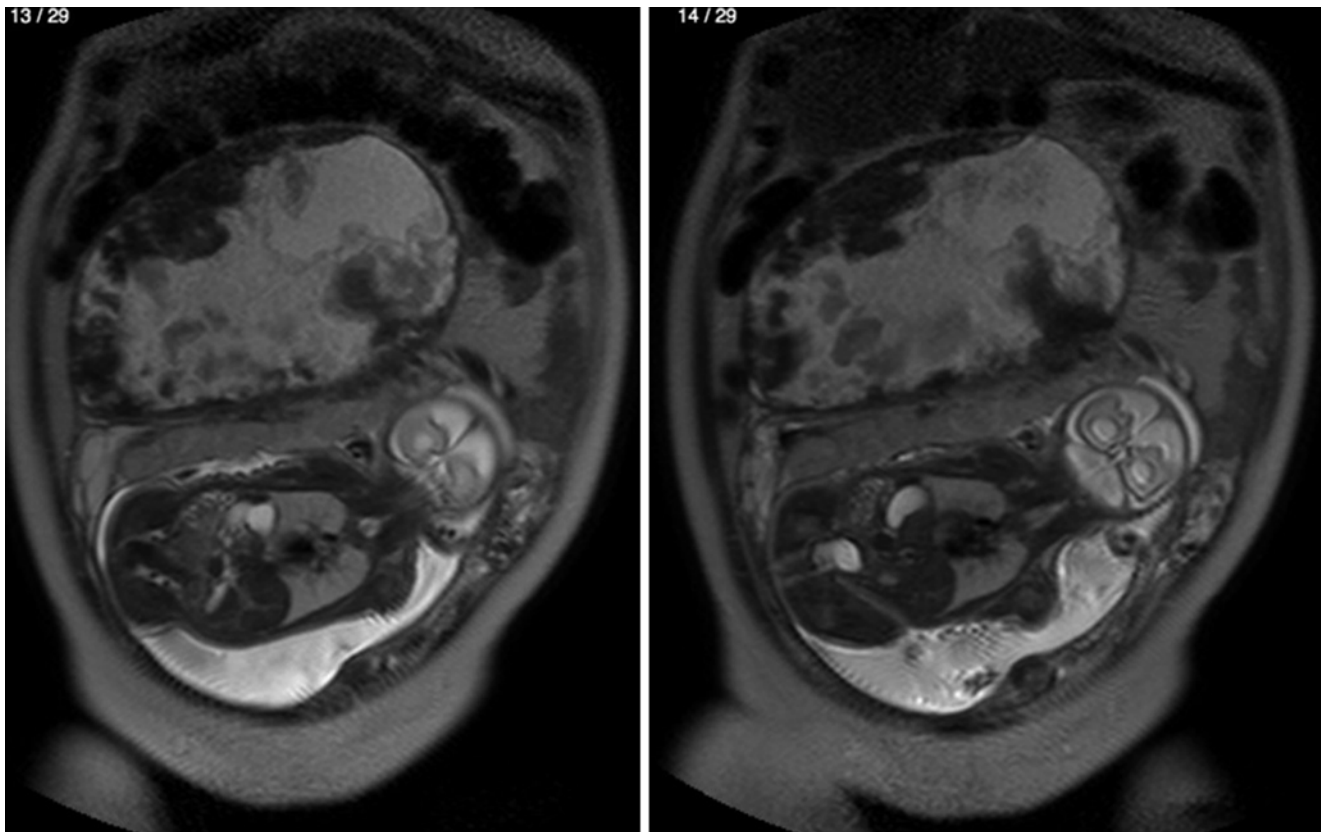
A MRI coronal scan showing a huge subserous leiomyoma in degeneration in a pregnant at 25 weeks
